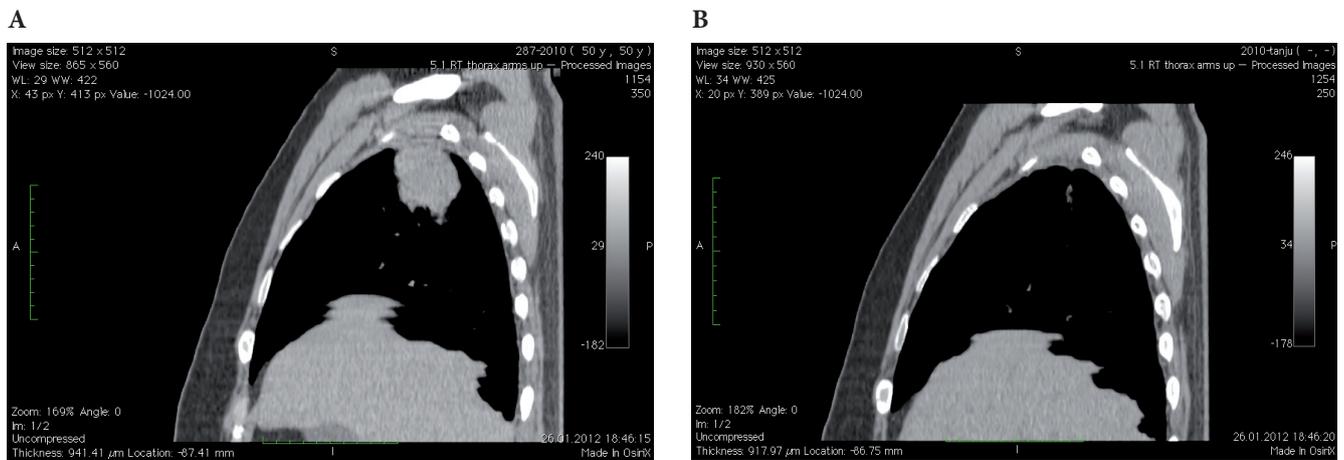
A. Pretreatment CT of a patient treated using ABC-mDIBH. B. Follow-up CT of the same patient at 3 months after completion of treatment using ABC-mDIBH
